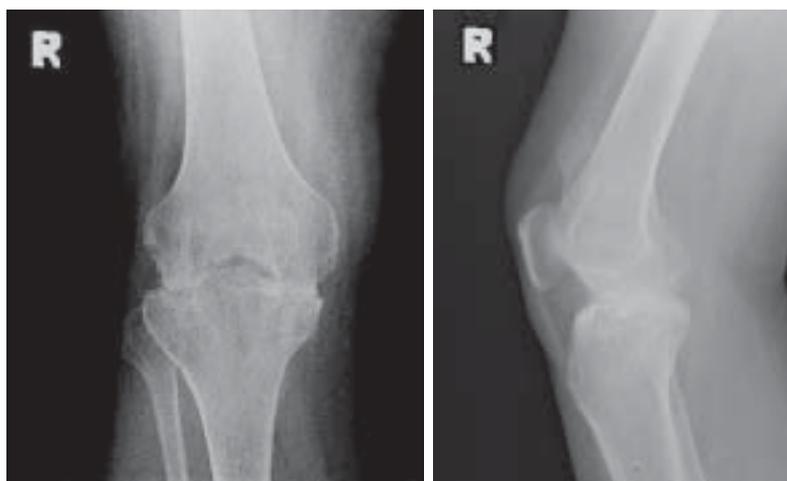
Radiograph of the right knee showing bony ankylosis.
